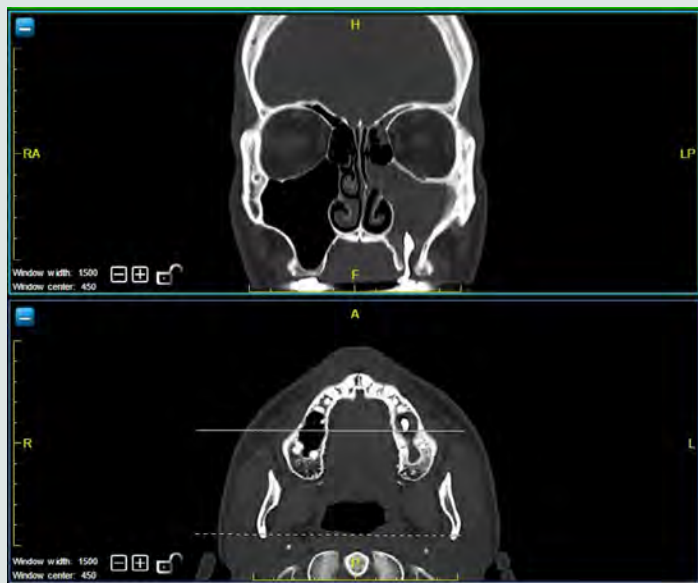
CT scan, coronal and axial views, in 2020 showing antral foreign body.
